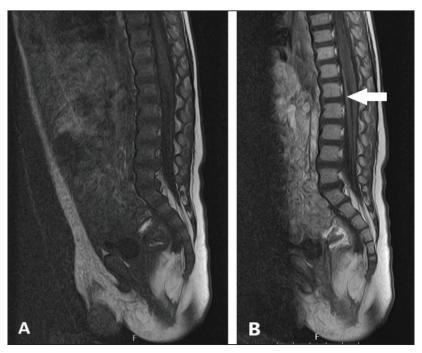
Axial FSET1-weighted MR image in native series (A) and after Gadolinium contrast injection (B) demonstrates post-contrast enhancement (white arrow) of the anterior spinal nerve roots.
